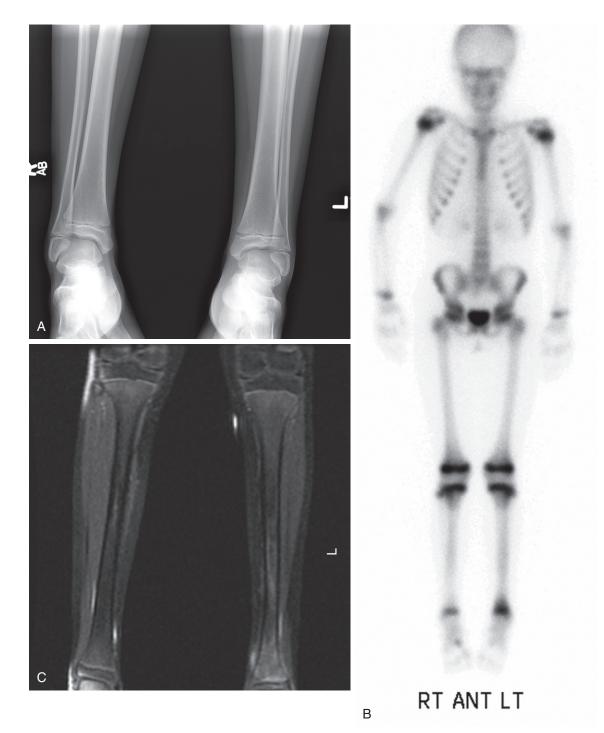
Technetium scan findings in acute osteomyelitis. This 10-year-old female presented with 3 days of left ankle pain and fever. A, A normal plain film of the ankle. B, Technetium scan demonstrated increased uptake in the distal tibial metaphysis. C, Coronal T₁ MRI with contrast showed bone marrow involvement. useful in resolving cases of pelvic osteomyelitis, where its resolution may help distinguish between joint disease, myositis, and true osteomyelitis. Acute osteomyelitis of the smaller bones comprising the hands and feet is a diagnosis that warrants MRI as the primary imaging modality.
